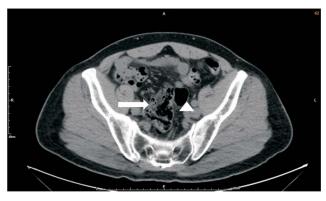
Axial abdominal computed tomography scan. The arrow indicates the cecum, and the arrowhead indicates the sigmoid colon.
